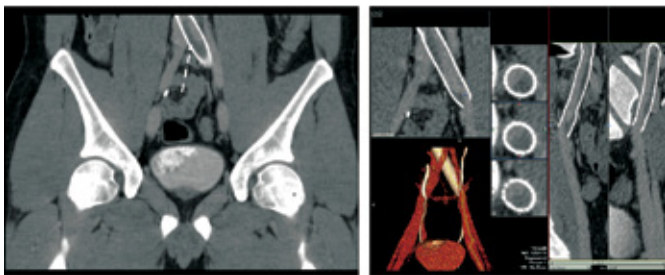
CT venography in a patient with recurrent left leg swelling a year after left common iliac vein stenting for May Thurner Syndrome. Notice the subocclusive thrombus within the stent. Venous Duplex was inconclusive.
